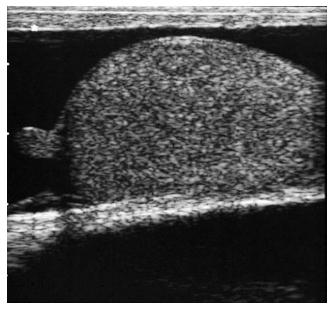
Sagittal sonogram of the right scrotum.
